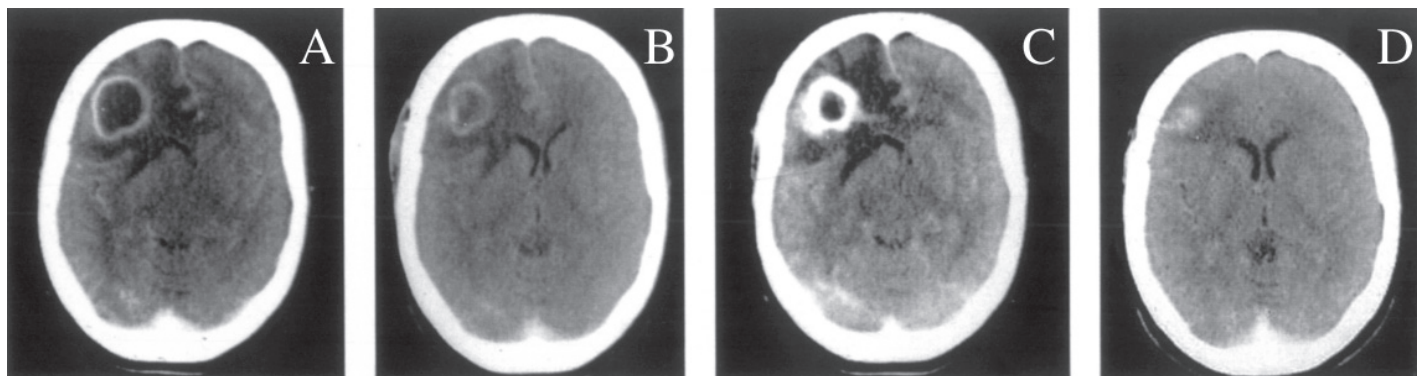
A and B were shown in the original report. A, pre-trepanation contrast CT scan showing a large abscess in the right frontal area. B, after one week of trepanation, CT scan demonstrates a marked diminution in the size of the lesion, residual enhancement and a moderate degree of edema. C, two months after trepanation, CT scan reveals worsening of the lesion, with important enhancement and a severe degree of edema. D, one month after, CT scan showing a residual nodular lesion.
